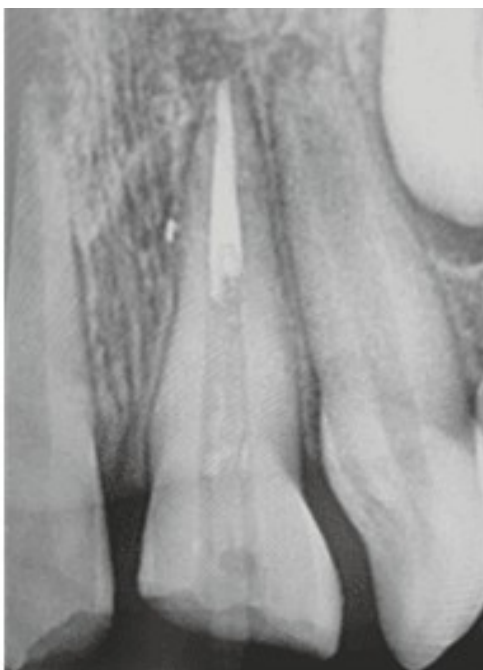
Radiograph after post space preparation on 21
